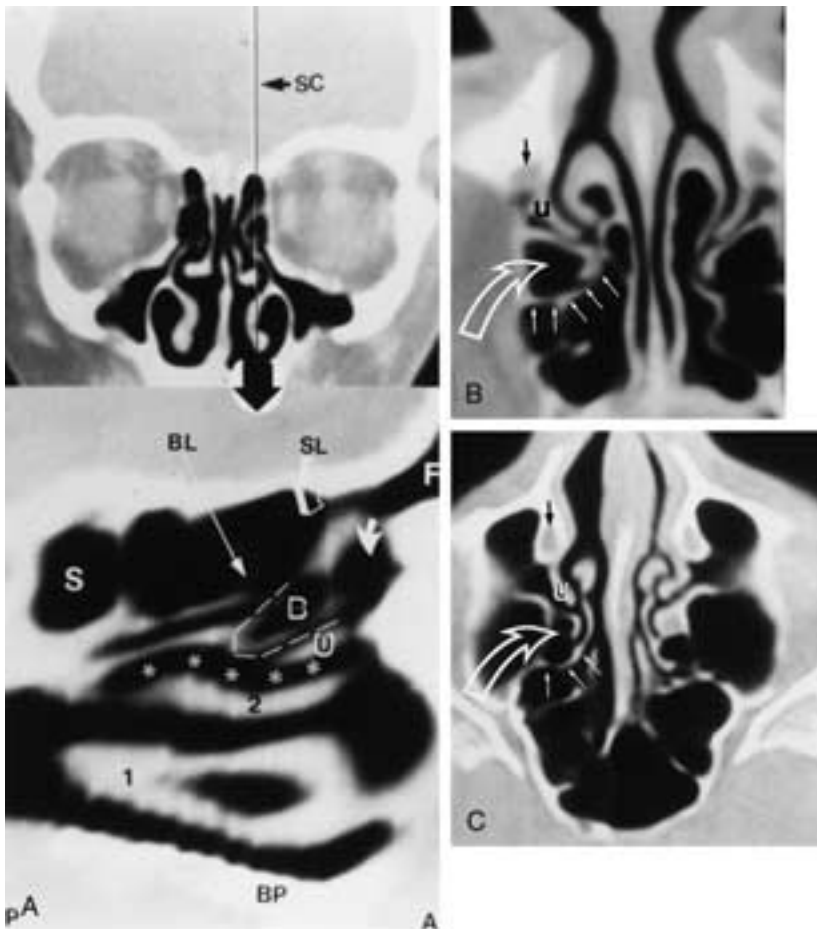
Anatomy of the basal lamella and sinus lateralis. A, Sagittal reconstructed plane (*SC*) from direct coronal CT data shows the outline of the basal lamella (*BL*) and the position of the sinus lateralis (*SL*) between the basal lamella and the ethmoid bulla (*B*). The position of the hiatus semilunaris (*dashed U-shaped line*), the frontal recess, and the anterior middle meatus (*curved arrow*) are noted. Frontal sinus (*F*), sphenoid sinus (*S*), uncinate process (*U*), middle meatus (*asterisks*), inferior turbinate (*I*), middle turbinate (*2*), bony palate (*BP*), anterior (*A*), and posterior (*P*). B and C, Axial CT images show the orientation of the uncinate process (*u*) and its association with nasolacrimal duct (*small black arrow*). Note the attachment of the basal lamella (*small white arrows*) to the lamina papyracea. The ethmoid bulla (*curved arrow*) is the air cell anterior to the basal lamella, and in both of these patients the posterior wall of the air cell is incomplete, providing direct communication between the ethmoid bulla and the sinus lateralis.
